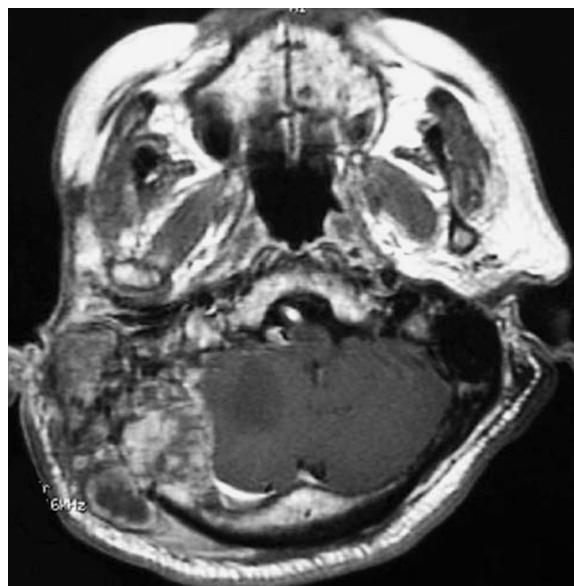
T1-weighted MR image with gadolinium enhancement showing a lesion with irregular enhancement located in the right posterior fossa destroying the bone structure.
